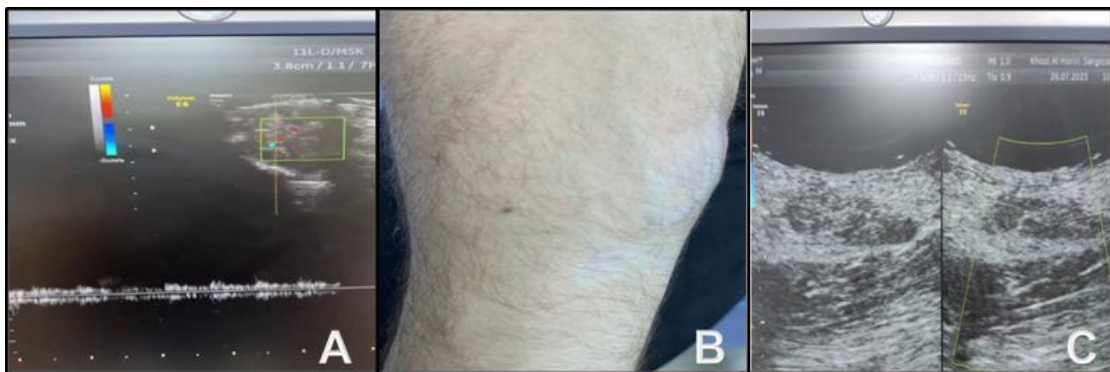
Young patient was treated with Bleomycin injection (A) Pulse Doppler before treatment (B) Arm swelling before treatment (C) Pulse Doppler after treatment.
